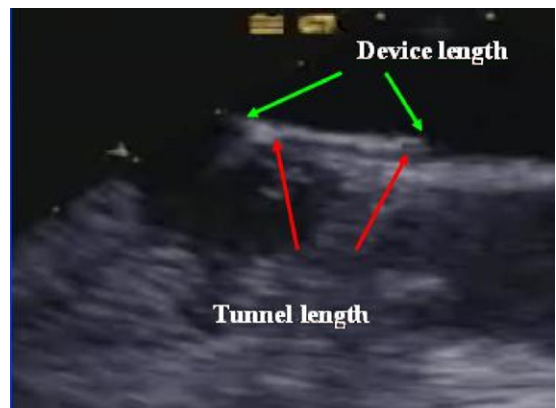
Transesophageal Echocardiography 6 Months After PFO Closure
